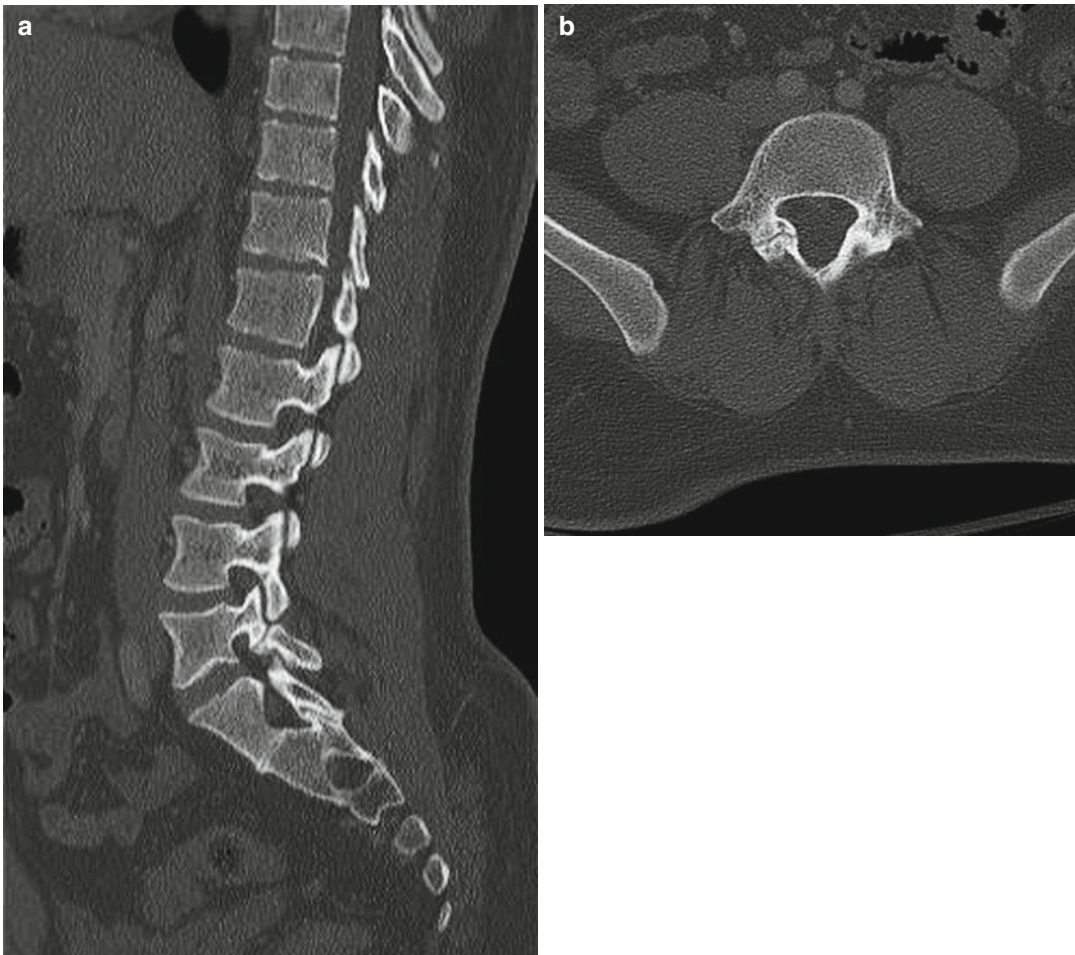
(a) Sagittal and (b) axial CT views displaying right pars interarticularis fracture of L5
